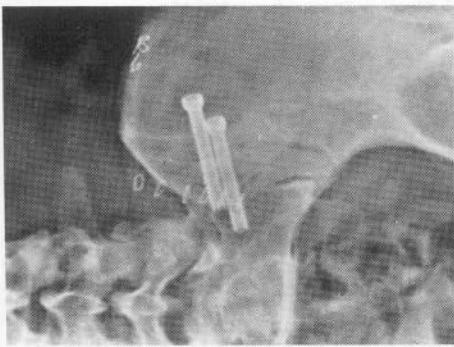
Post-operative x-ray showing two cannulated screws bridging ilium and sacrum
